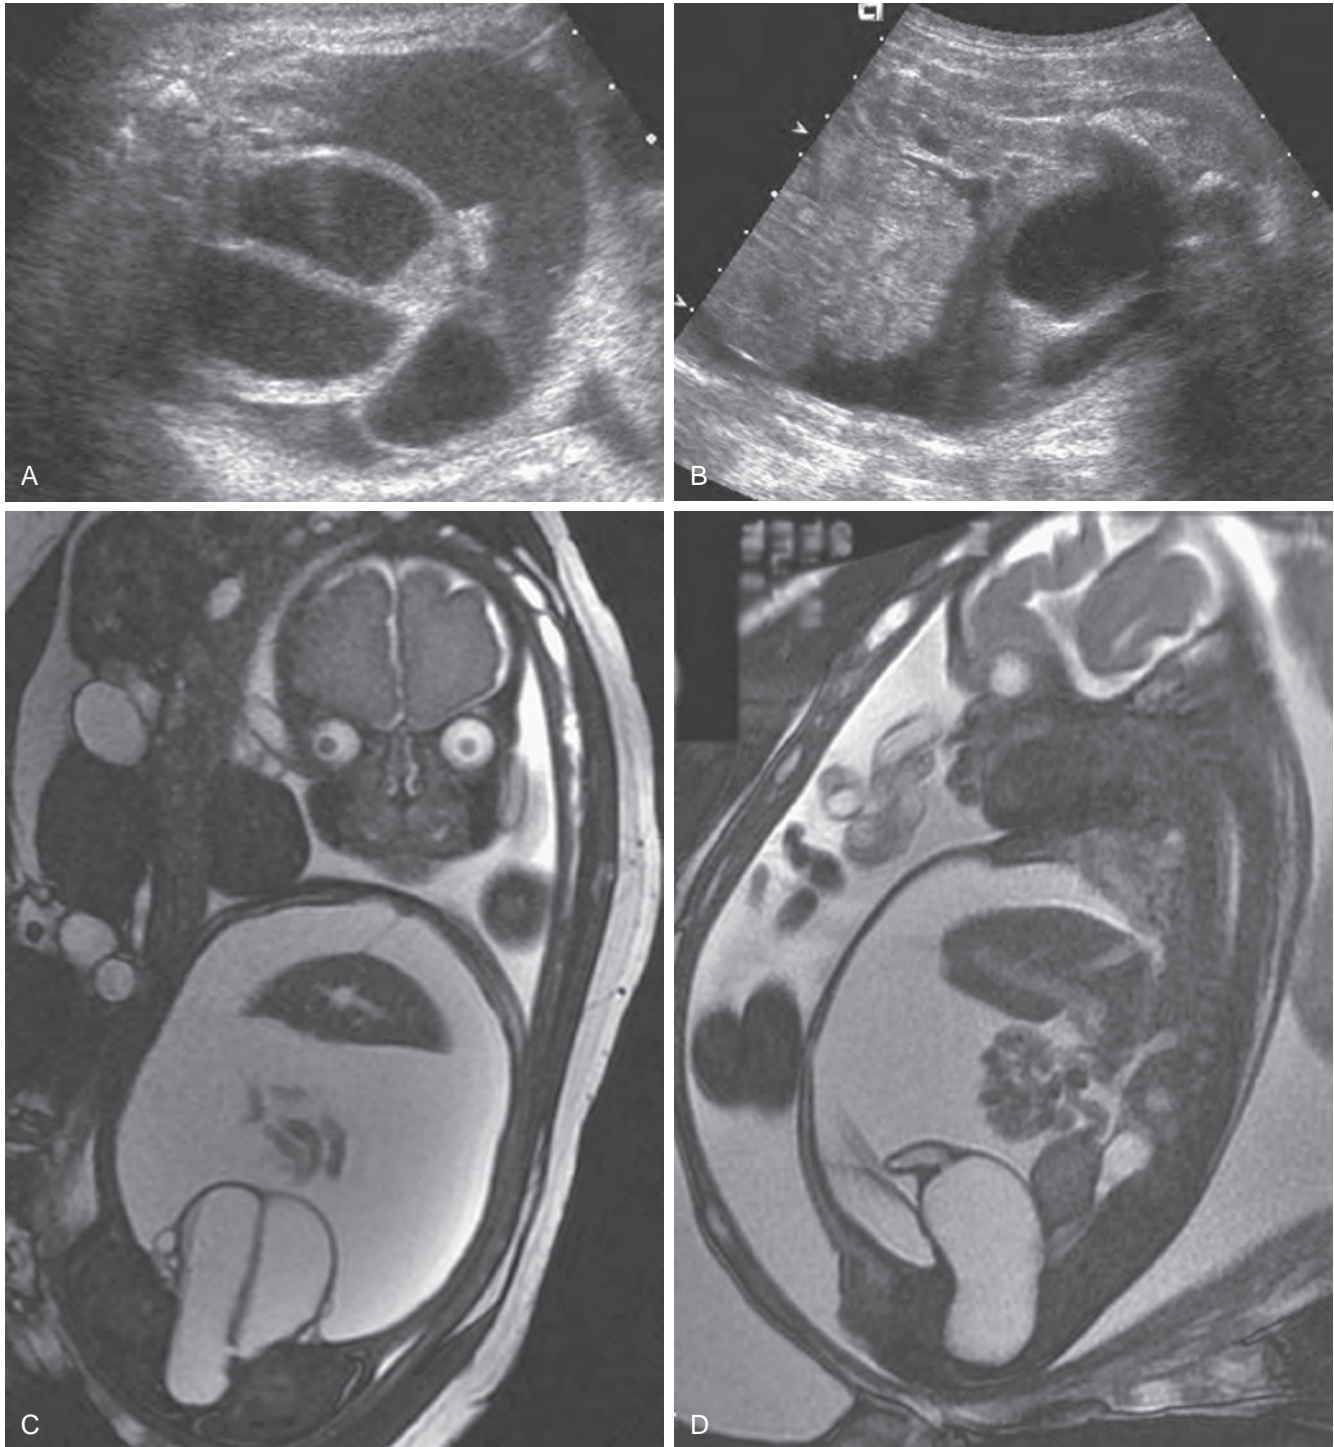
Imaging of a female fetus at 30 weeks' gestational age with cloaca. A, Transverse ultrasound view of abdomen showing dilated duplicate vagina, urinary bladder, and urinary ascites consistent with cloaca. B, Sagittal ultrasound image showing bladder, markedly distended vagina, kidney with mild hydronephrosis, and urinary ascites outlining bowel and liver. C, Coronal magnetic resonance image showing duplicate vagina and urinary ascites. D, Sagittal magnetic resonance image of bladder, distended vagina, cervix, uterus, and intra-abdominal organs outlined by urinary ascites.
